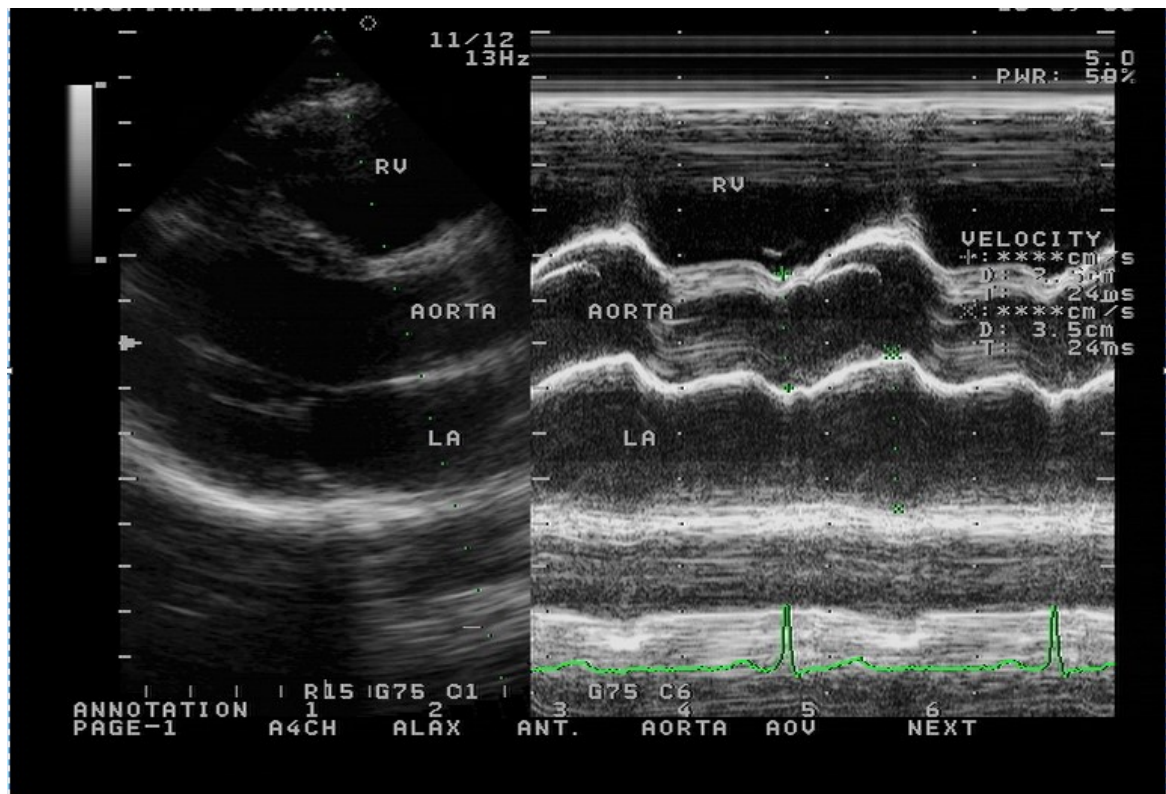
M-Mode Echocardiogram Showing Measurement of Aortic Root and Left Atrial Diameter
